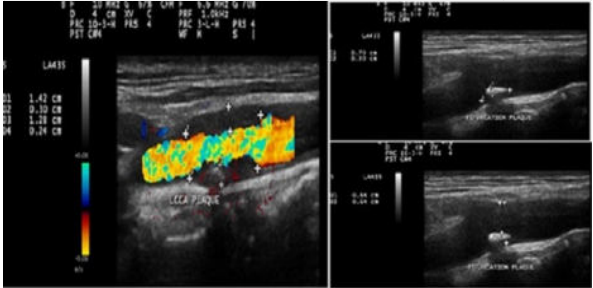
Colour doppler image showing calcified ulcerated plaque in Left CCA, Gray scale sonography image showing calcified smooth plaque at bifurcation, Gray scale sonography iamge showing diameter method for calculation of stenosis(C-B/Cx100)
